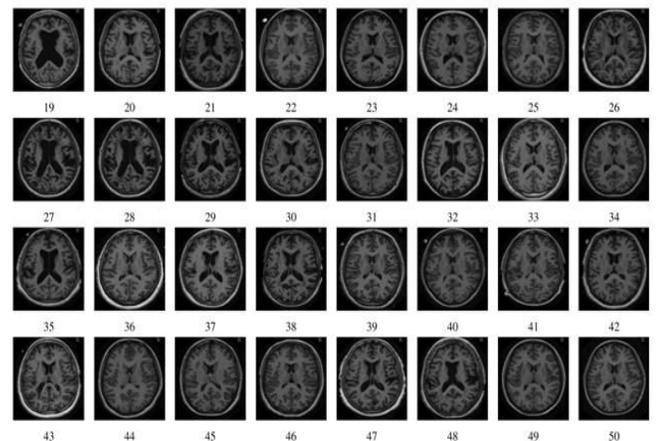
Brain MRI Images Without Tumor
